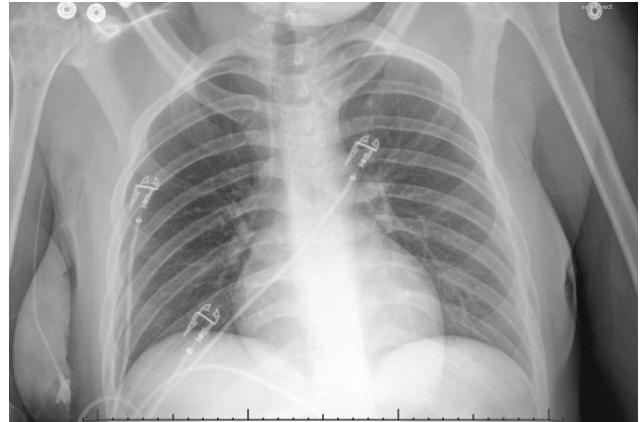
Chest radiography showed no airspace abnormalities or hilar abnormalities.
